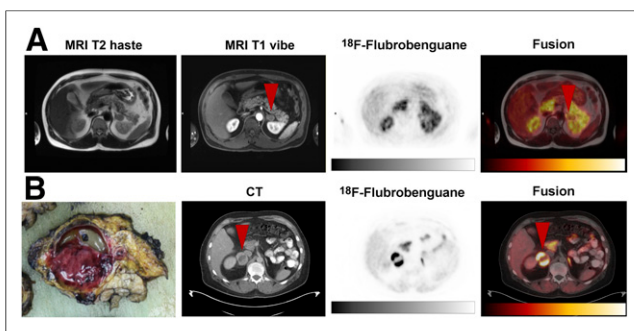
Case examples of adrenal adenoma and pheochromocytoma. (A) A 50-year-old man with hypertension and unclear lesion in left adrenal gland. ^{18}F -flubrobenguane PET/CT showed only mild tracer uptake (arrowheads), and surgical resection diagnosed aldosterone-producing adenoma. (B) A 57-year-old man with pathologically elevated metanephrine concentration in plasma. Pheochromocytoma (arrowheads) was detected in right adrenal gland on ^{18}F -flubrobenguane PET/CT by increased tracer uptake in lesion but focal lack of uptake in central necrotic tissue, as was verified after surgical resection. haste = half-Fourier-acquired single-shot turbo spin echo.
